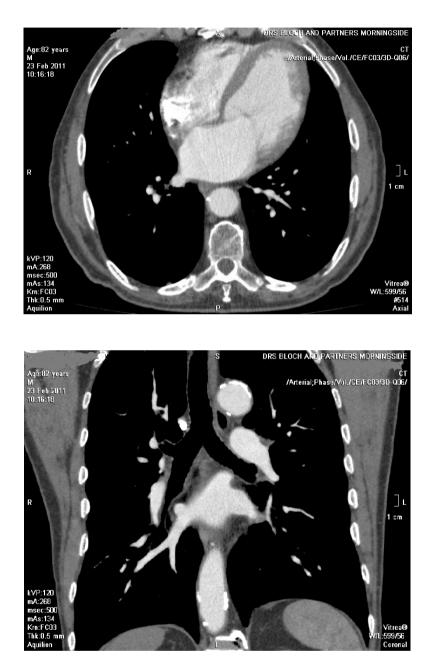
Chest CT Scan images demonstrating a normal chest pathology in an 82 year old male. Permission granted from Drs Bloch and Partners Morningside MediClinic Radiology Department.
